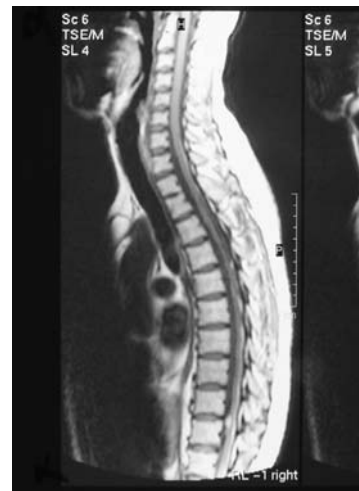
Hyper signal lesion in T1-MRI sequence at T11-12 level.
